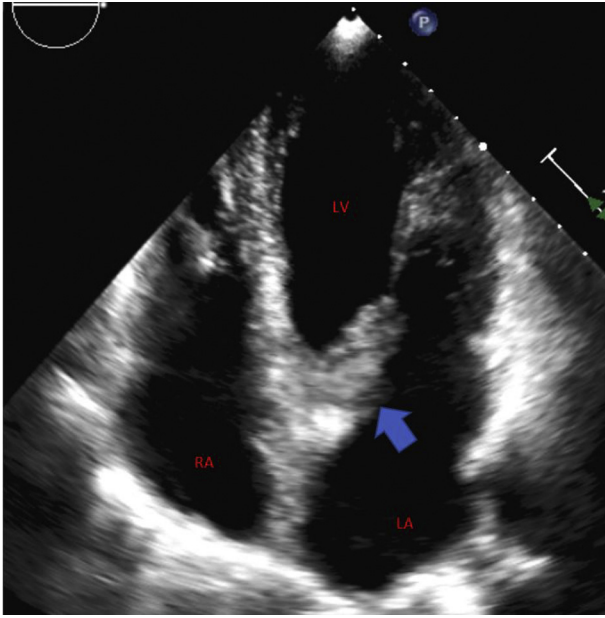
Four-chamber echocardiographic view showing homogenous thickening of valvular apparatus (arrow). LA, Left atrium; LV, left ventricle; RA, right atrium.
